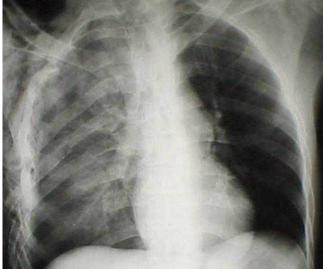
RADIOGRAPHIC SIGNS OF PULMONARY CONTUSION. Mottling may be subtle. Note the rib fractures, and subcutaneous emphysema. Contusion is usually associated with obvious rib fractures in adults, but may be seen in children without, since their ribs are compliant so that they bend rather than break.
